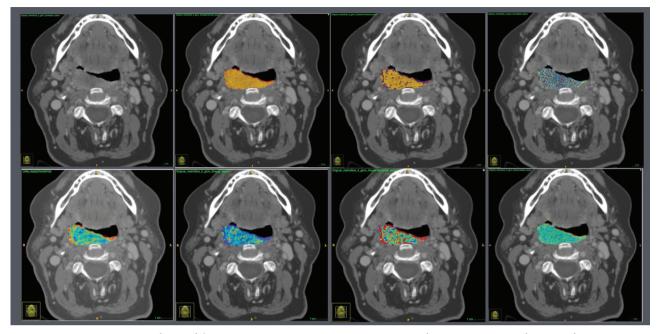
Various texture maps obtained from post contrast CT images in a patient with HPV positive oropharyngeal carcinoma.
